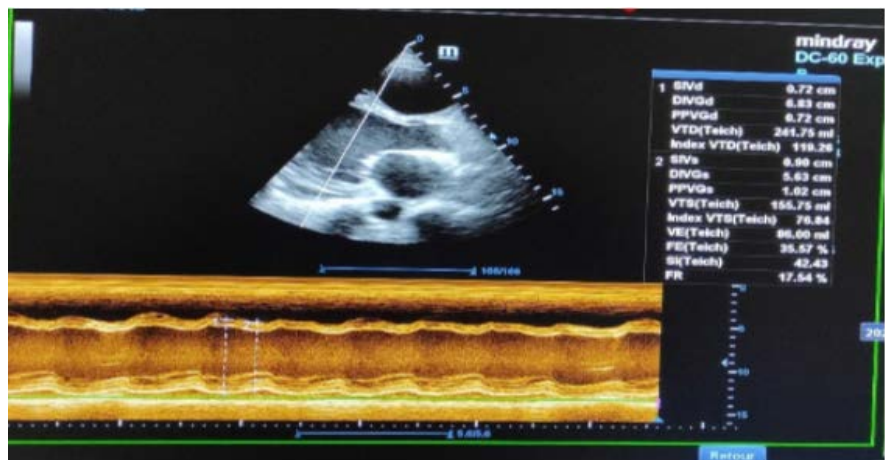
Transthoracic echocardiography in the parasternal long axis window using the TM mode showing dilatation and global hypokinesia of the left ventricle in a patient with peripartum cardiomyopathy in Parakou in 2022.
